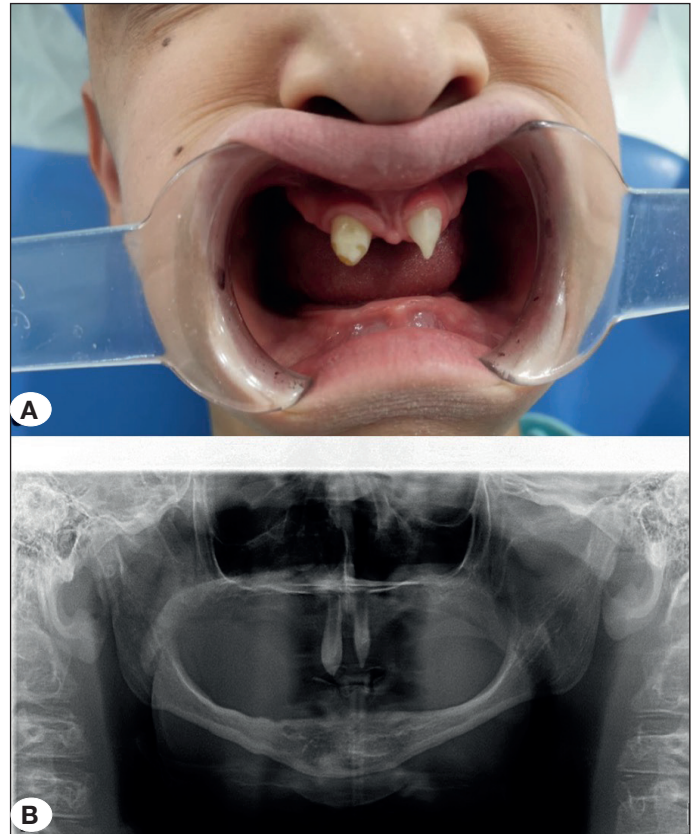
A) Intra-oral view of maxilla and mandibula (conic-shaped maxillary central incisors and mandibular anodontia). B) Panoramic radiography of case 1.
